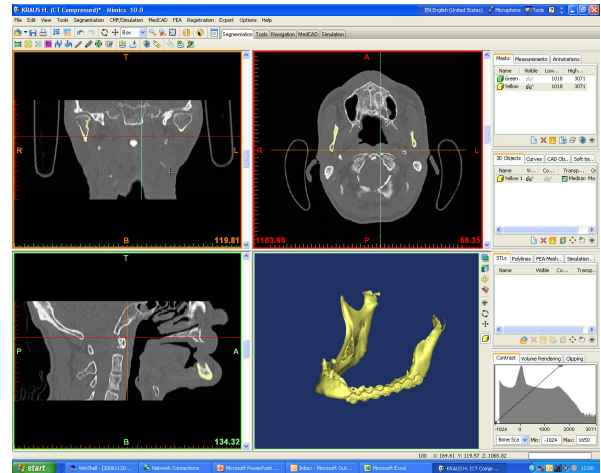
CT-scan of the mandibula
